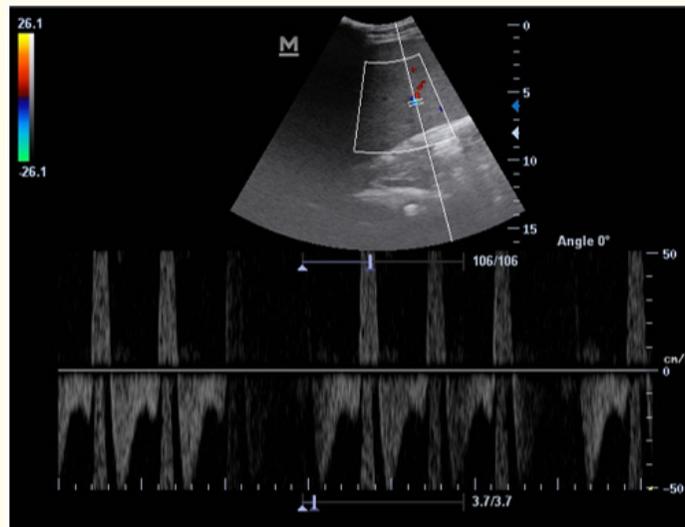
Spectral Doppler of splenic artery branch reveal.
